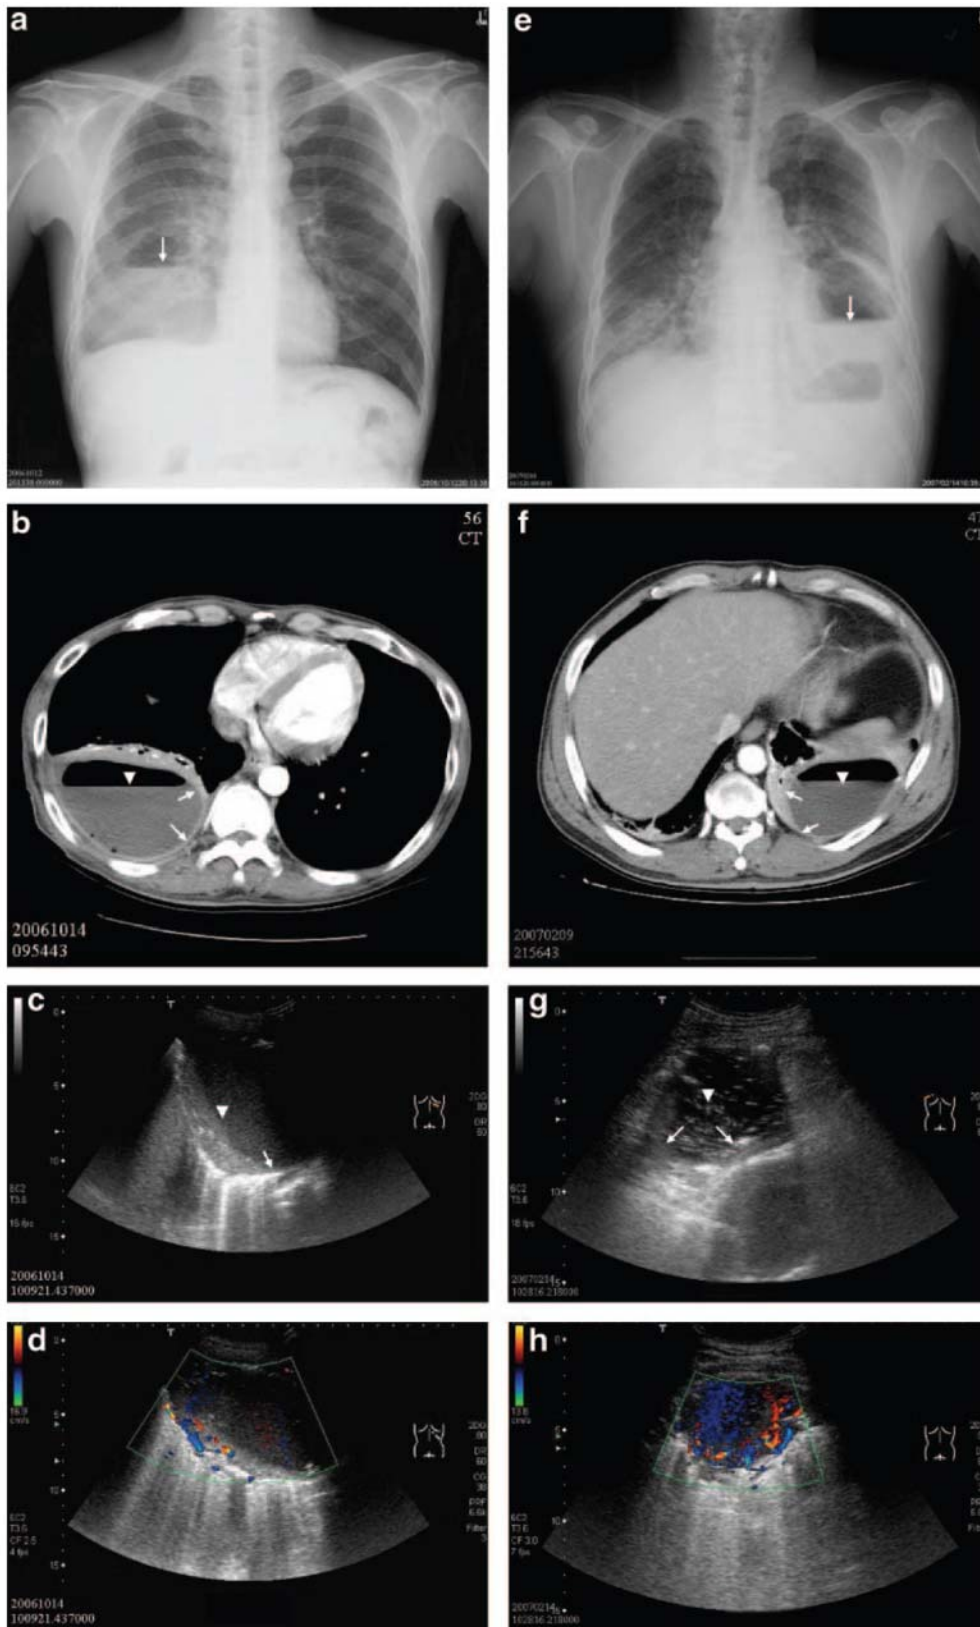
Top left, a, to bottom left, d:* empyema. *Top left, a:* chest radiograph of a 39-year-old man shows an air-fluid level (arrow) in the right lower lobe. *Top center left, b:* CT scan image shows a cavitary lesion with an air-fluid level (arrowhead) and split pleura sign (arrow). *Bottom center left, c:* grayscale ultrasound examination reveals a band-like shape with smooth margin and straight air-bronchograms (arrowhead) [not like typical pulmonary consolidation characterized by irregular, serrated, and somewhat blurred margin and a marked tree-shaped air bronchogram with ramifications]. The band-like shape does not surround the air-fluid lesion continuously (arrow), which is a typical
